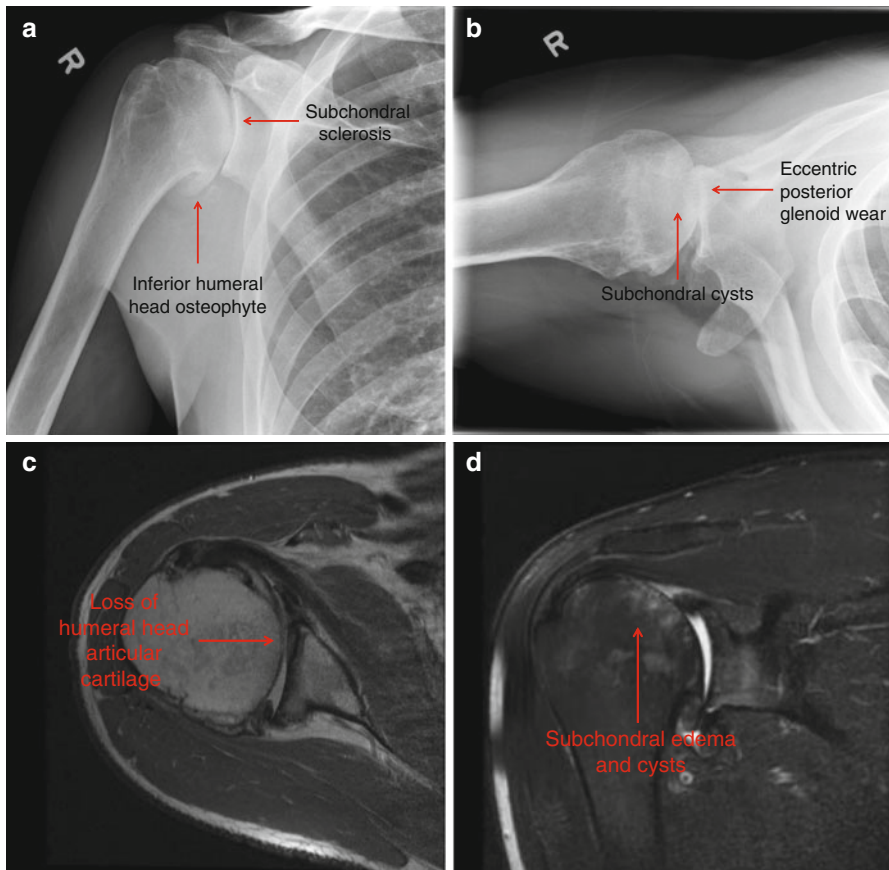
Shoulder osteoarthritis. (a, b) Demonstration of the typical radiographic appearance of primary shoulder osteoarthritis in the anteroposterior and axillary views, respectively. Typical radiographic features include an inferior humeral head osteophyte (a), subchondral sclerosis (a), subchondral cysts (b), and eccentric posterior glenoid wear (b). (c, d) Demonstration of corresponding coronal and axial MRI views of the same patient, respectively. In these images, there is complete loss of articular cartilage on the humeral head (c), subchondral cysts (d), and subchondral bone edema (d)
